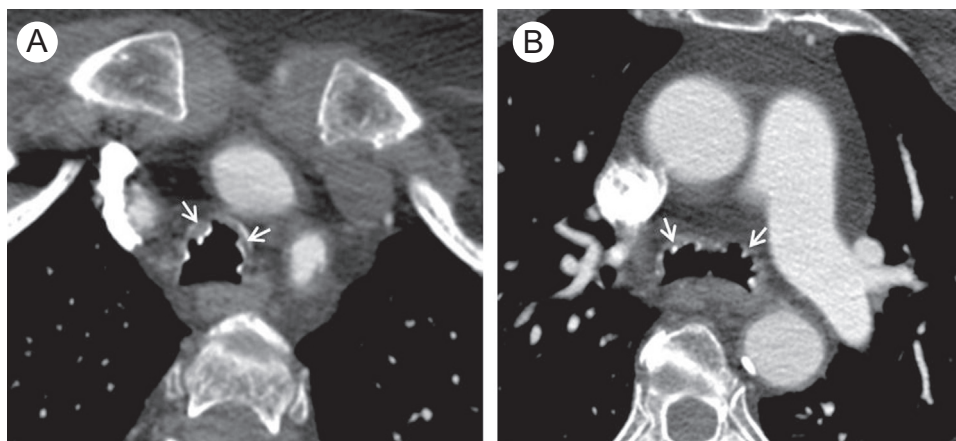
Tracheobronchopathia osteochondroplastica. Axial CT images showing calcific nodules arising from the tracheal cartilage in (A) and right and left bronchial cartilage in (B) (arrows). Note that the nodules spare the posterior membrane.
